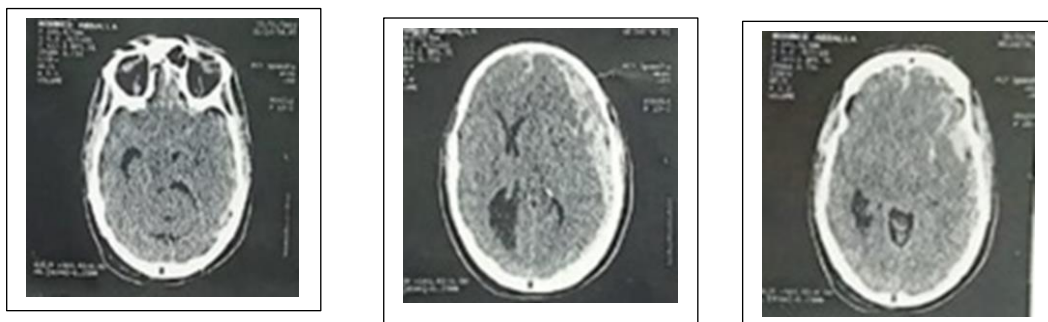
shows CT brain of 55 years old male patient presented by head trauma (The Helsinki Score 11/14: Obliterated Cistern:5, Subdural Hemorrhage 2, Intracerebral Hemorrhage 2, mass lesion>25cm²), (The Rotterdam Score 6/6 : Absent basal cistern:2, Midline shift more than 0.5cm:1 , Absent epidural Hematoma: 1 Traumatic SAH:1), The Marshall Score VI: High or mixed density lesions >25 cm³ not surgically evacuated)
